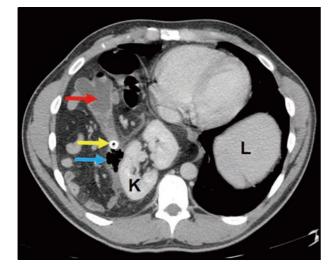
Transverse CT scan demonstrates cecum (red arrow), dilated lumen of appendix with appendicolith (yellow arrow) and secondary to acute appendicitis periappendicial mass with abscess and gases in the right infradiaphragmatic region (blue arrow). K: Kidney; L: Liver.
